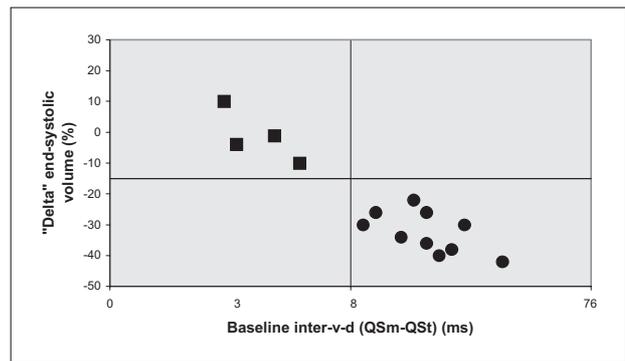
Correlation between pre-implantation interventricular dyssynchrony and reverse remodeling after cardiac resynchronization therapy. *inter-v-d* = interventricular delay; *QSm* = interval between *Q* wave and tissue Doppler *S* wave on the mitral annulus; *QSt* = interval between *Q* wave and tissue Doppler *S* wave on the tricuspid annulus. Circles: responders; squares: non-responders.
